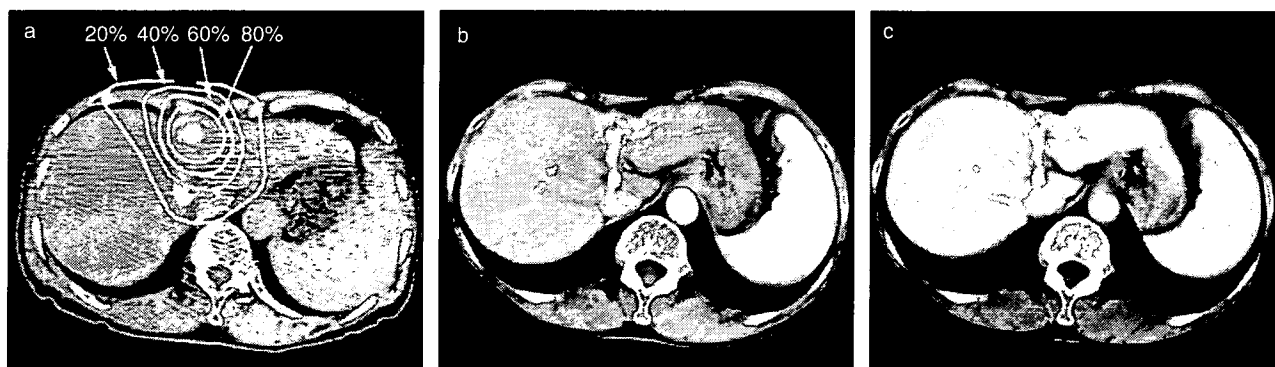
Computed tomography (CT) in patient 9. (a) Lipiodol pooled in the primary lesion before irradiation. The isodose curves for 20%, 40%, 60%, and 80% of the maximum dose are indicated. (b) Arterial phase CT 74 weeks after irradiation. Lipiodol remains pooled and contrast enhancement is observed in the high-dose area surrounding the primary lesion. (c) Portal phase CT 74 weeks after irradiation. Residual contrast enhancement is observed in the area surrounding the tumor. These enhancements are post-irradiation changes.
